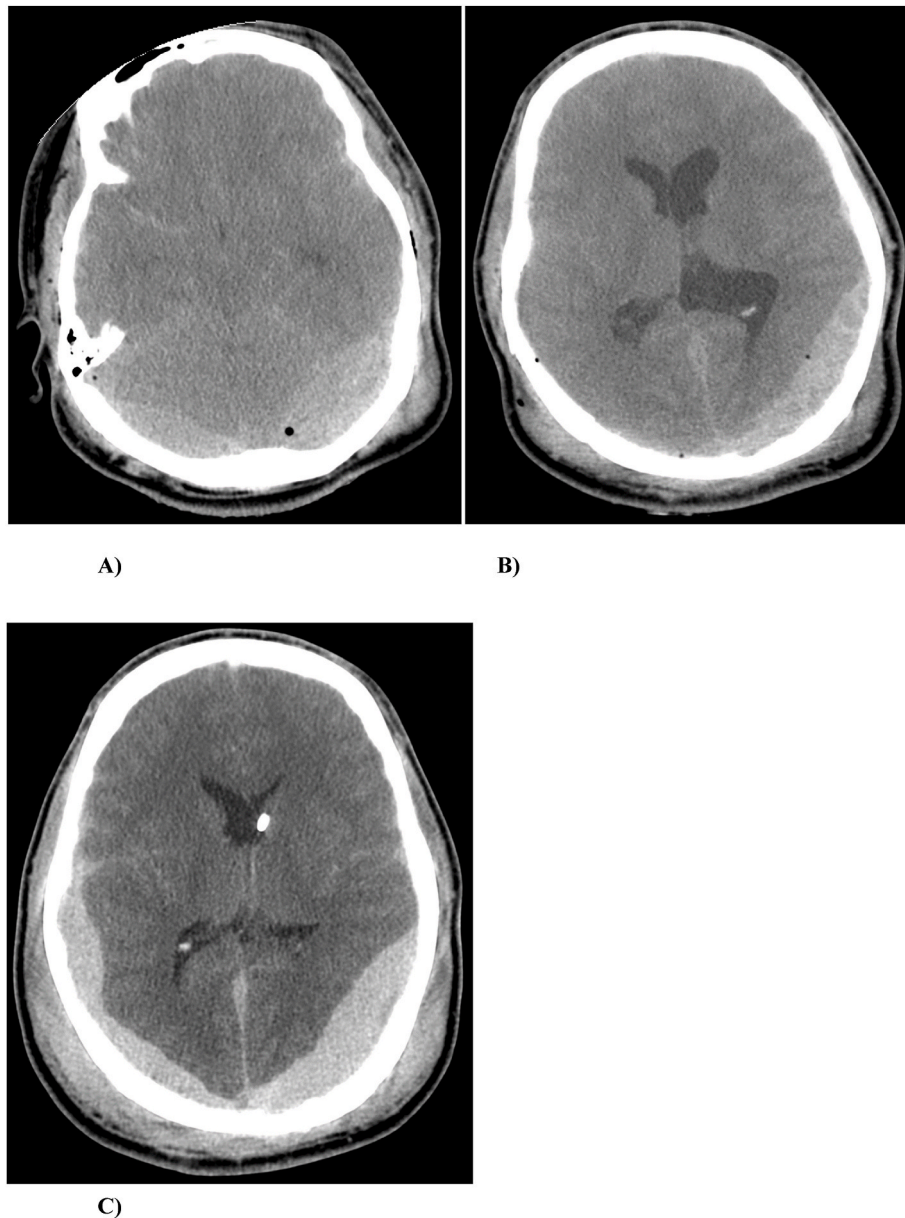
(A–C) A) A 21-year-old male fell out of a driving vehicle and presented in a deeply comatose state with a GCS score of 3, anisocoric, non-reactive pupils, without other brain stem reflexes, but present agonal respiratory efforts. CT revealed an EDHPF along with diffuse brain edema, traumatic frontal contusion, and subarachnoid bleed, extensive skull base fractures involving bilateral petrous bones, B) as well as early developing hydrocephalus. C) An immediate external ventricular drain was placed to treat the associated hydrocephalus secondary to spinal fluid flow obstruction caused by the EDHPF. However, due to rapid progression of the EDHPF and the overall poor prognosis for recovery the family elected against further procedures and the patient died from his head injury.
